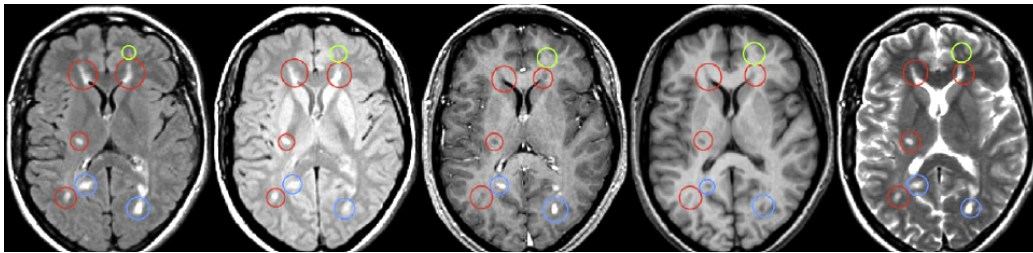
Example of MS lesions on MRI. From left to right: FLAIR, PDw, Gd-enhanced T1w, T1w, and T2w images. Several types of MS lesions can be observed: Enhancing lesions (blue), lesions visible only on T2w (green), black holes (red). In Gd-enhanced T1w and FLAIR images, multiple bright regions are observed that may be mislabeled as lesions. courtesy: [Garcia-Lorenzo 2013]
